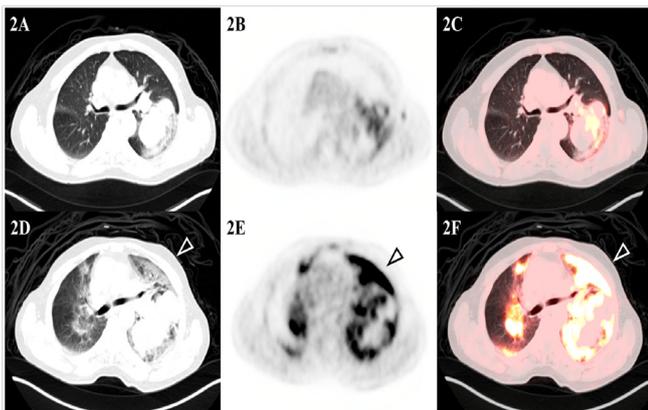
Patient 1 Axial FDG PET/CT images. Top row (2A-C) demonstrates baseline axial CT (2A), axial PET (2B), and axial fused PET/CT (2C) images of the chest obtained 1 month after diagnosis with FDG-avid 11 cm left lung mass. Bottom row (2D-F) demonstrates 8-month follow-up axial CT (2D), axial PET (2E), and axial fused PET/CT (2F) images with significant interval progression of FDG-avid disease. New FDG ground glass lung opacities were favored to represent lymphangitis carcinomatosa (open arrowhead).
